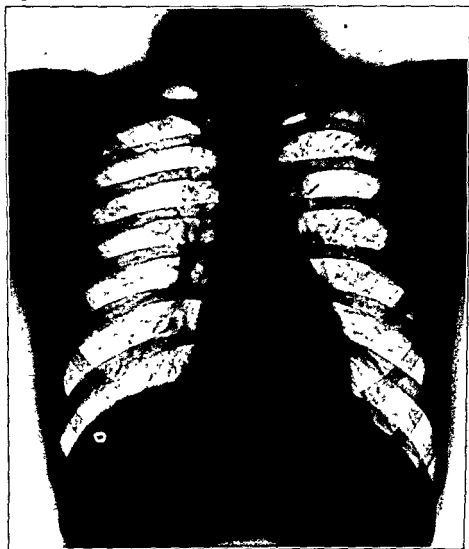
An x-ray one year after Fig. 66. The boy's weight had increased from 92 to 130 pounds. There has been a slight extension of the disease.
